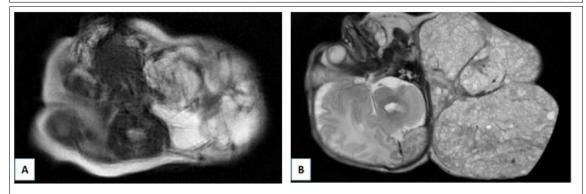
MRI scan showed a solid and cystic mass in the neck extended to the scalp, associated with calcifications
